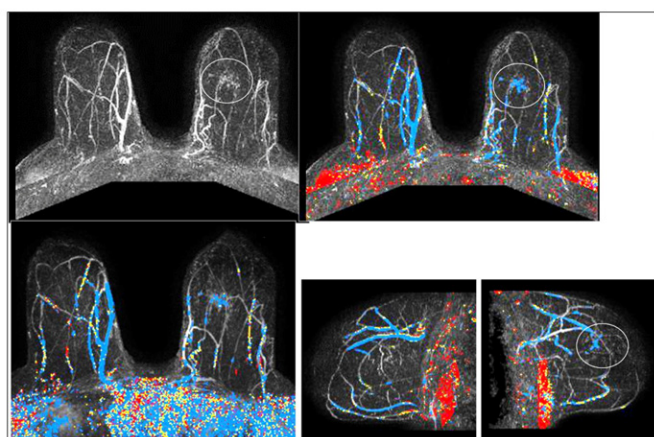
Breast MRI examination demonstrates the presence of the pathologic lesion, but the MRI extent of the tumour is smaller than on the mammograms or on ultrasound examination.
